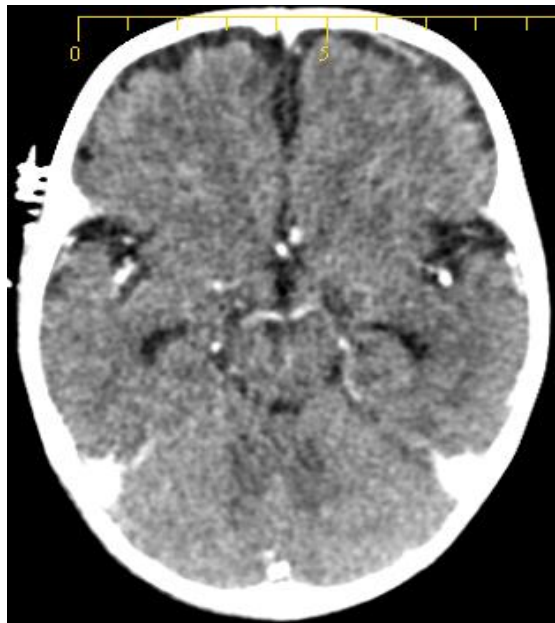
Image of CT brain post-contrast, for 1 year child. Acquired by 80 kV, 247 mAs, TCM, CTDI_{vol} 12 mGy (Siemens 128 FLASH MDCT)
